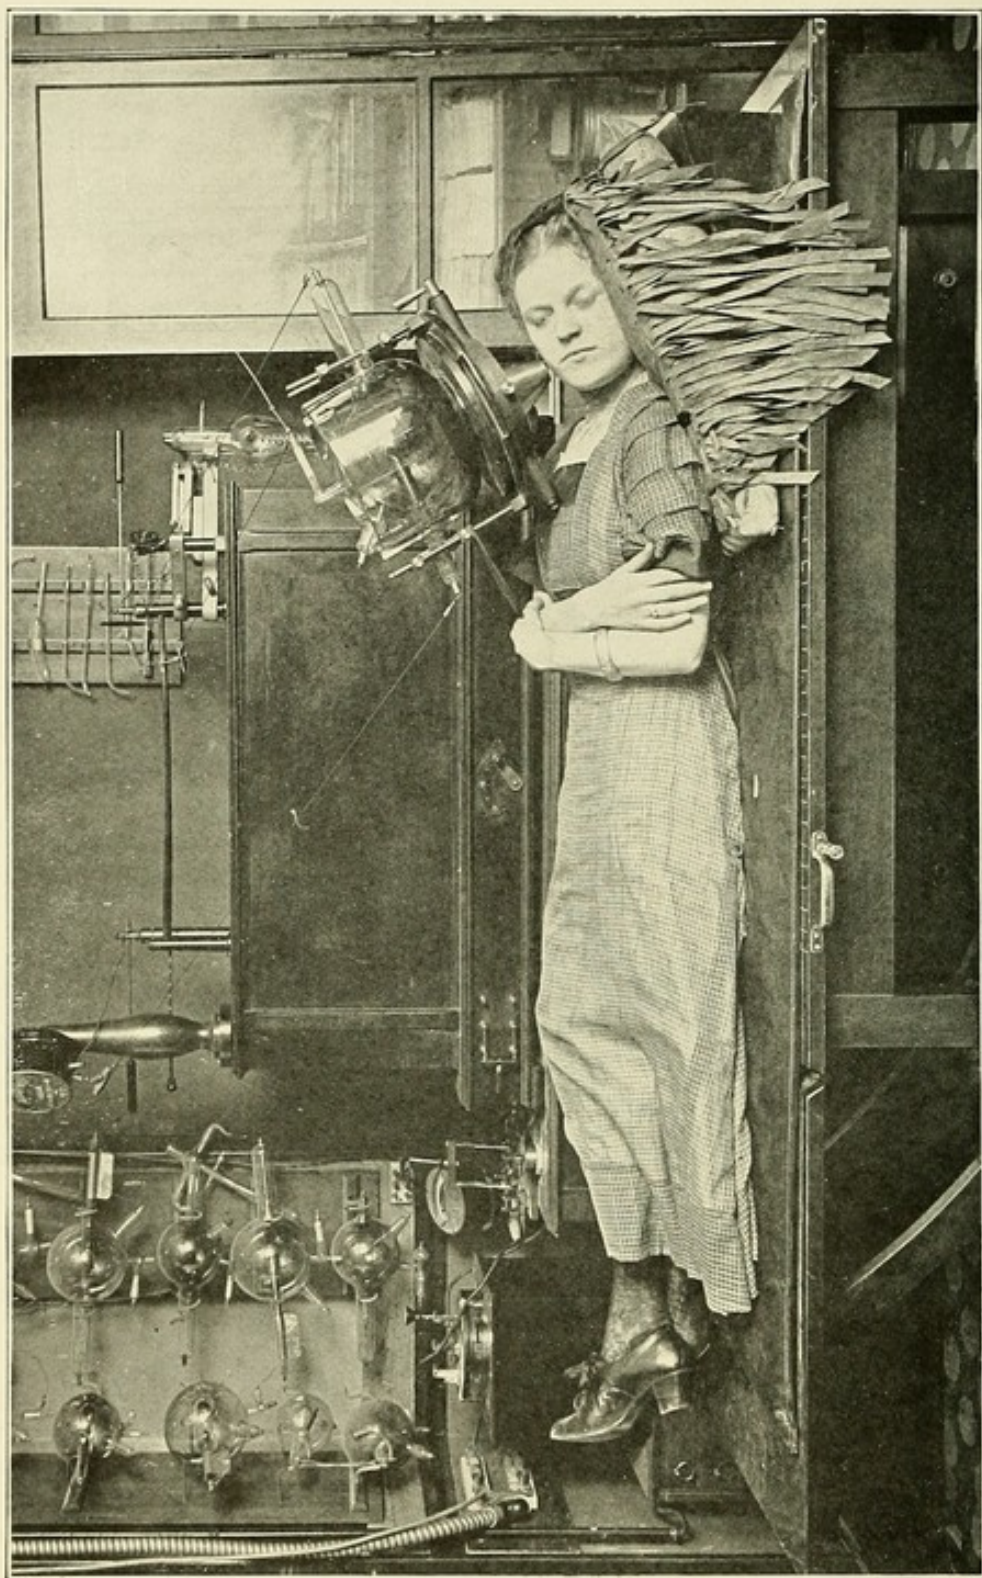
Method of x-ray treatment for cancer of the face.
